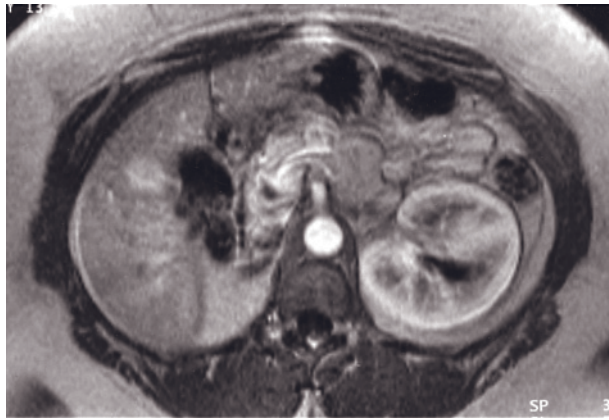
Renal hypertrophy. T1-weighted immediate postgadolinium SGE image demonstrates generalized enlargement of the left kidney with uniform thickness of renal cortex. This adult patient had undergone a right nephrectomy.
